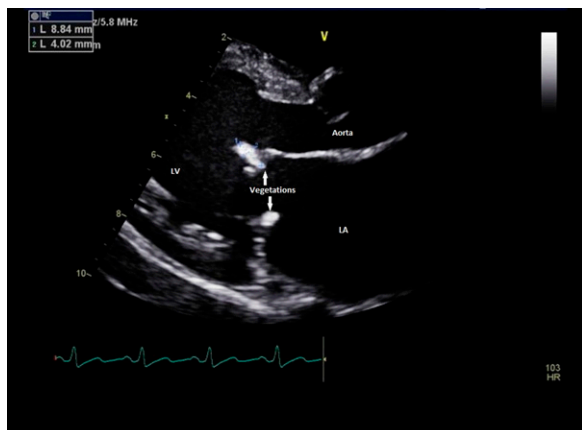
Echocardiogram showing vegetations attached to the mitral valve. LA=left atrium; LV=left ventricle.
